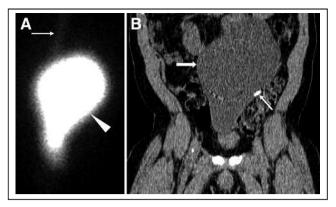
(A) Planar scintigraphy of abdomen demonstrates well-defined loculated activity in abdomen (arrowhead), as well as part of distal tubing in upper abdomen (arrow). (B) Coronal CT depicts correlating large pseudocyst occupying abdomen and pelvis (thick arrow) with fluid density and thin wall, as well as distal end of shunt catheter tip terminating within pseudocyst (thin arrow).
